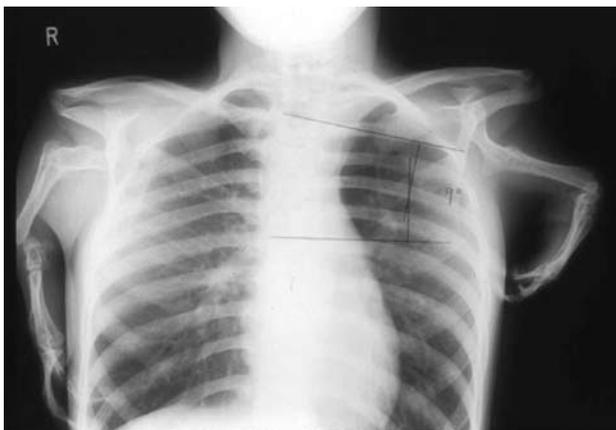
X-ray of a patient with phocomelia
